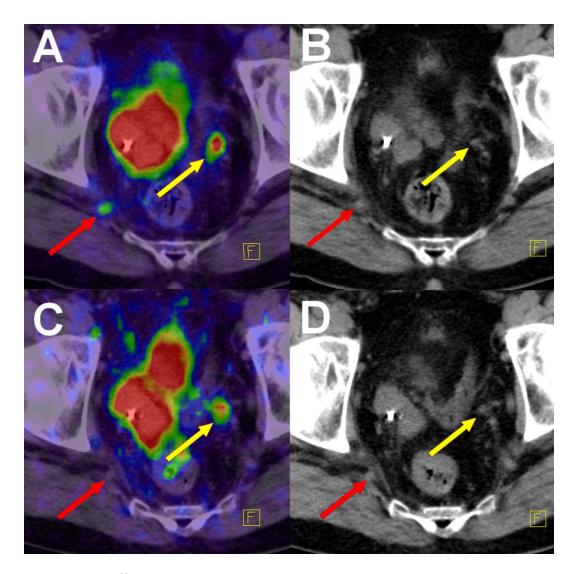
⁶⁸Ga-PSMA-11-PET/CT of a patient at 1h p.i. (A, B) and at 3h p.i. (C, D). Red arrows point to a lesion (LN) characteristic for PCa in early images which, however, became invisible in late scans. Another LN metastasis (yellow arrows) presented also with decreasing uptake and contrast in late scans (SUVmax: 5.0 at 1h p.i. and 3.5 at 3h p.i., contrast: 4.7 at 1h p.i. and 3.3 at 3h p.i.). A: fusion of PET and CT at 1h p.i., B: low dose CT at 1h p.i., C: fusion of PET and CT at 3h p.i., D: low dose CT at 3h p.i..
